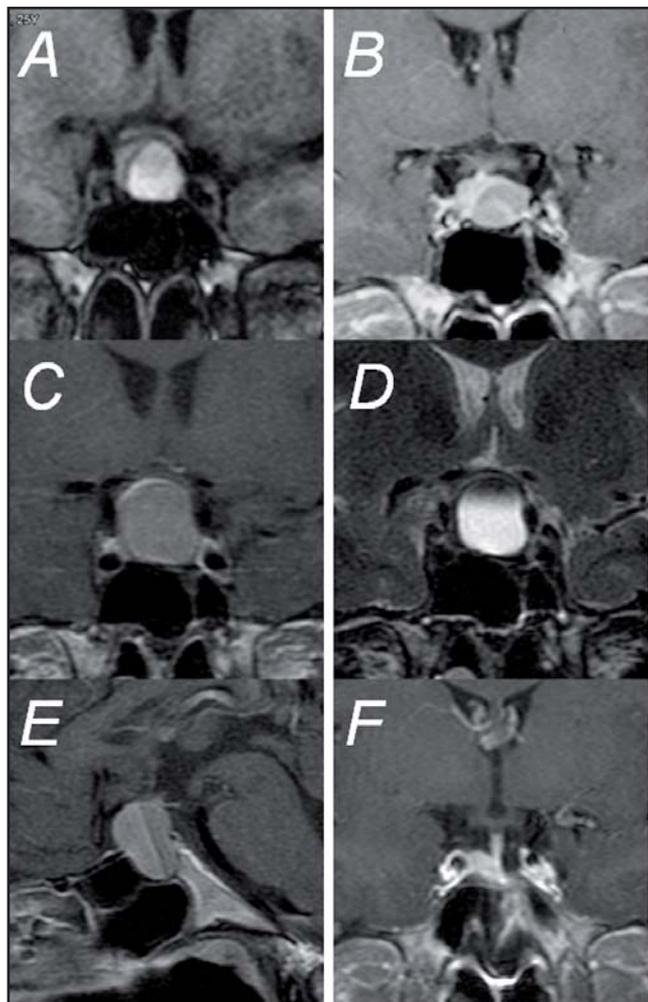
MRI scans of the pituitary tumor in the presented patient (October 2007 – March 2010). A – initial MRI scans showing intra- and suprasellar pituitary adenoma (16x12x14 mm) compressing and displacing optic chiasm (coronal T1-weighted scans). B – tumor shrinkage after treatment with bromocriptine shortly before pregnancy (coronal T1-weighted scans) C,D,E – MRI images of pituitary-tumor apoplexy: Preoperative MRI (20th week of pregnancy) presenting enlargement of the preexisting pituitary mass (19x15x16 mm) - large hypointensive (Fig. 1C - coronal T1-weighted image) and hyperintensive (Fig 2D - coronal T2-weighted scan) intra- and suprasellar mass suggesting hemorrhage within a pituitary tumor, compressing the optic chiasm and displacing both cavernous carotid arteries. Note the hyperintensive area on Fig. 1E presenting subacute hemorrhage (sagittal T1-weighted MRI). F – Postoperative, follow-up MRI scan (2 years after surgery) depicted secondary (postoperative) empty sella. Small, isointensive pituitary gland is located on the right side of the enlarged sella. On the left side herniation of the suprasellar subarachnoid cistern through a widely opened diaphragm is visible. The pituitary infundibulum maintains a midline position. No tumor recurrence is noted (coronal T1-weighted scans).
